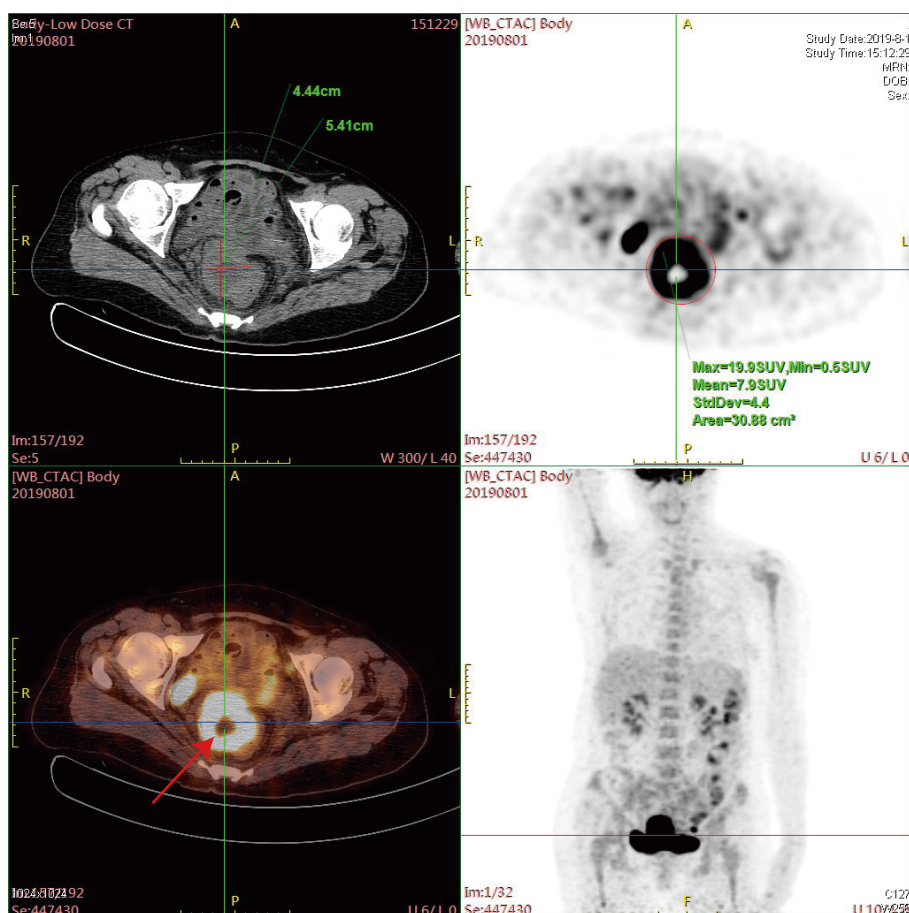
Positron emission tomography (PET)/computed tomography (CT) imaging showed multiple pelvic metastases with increased fluorodeoxyglucose (FDG) activity, meaning recurrence occurred 2 months after the first operation. The arrow indicates the location of the lesion.
